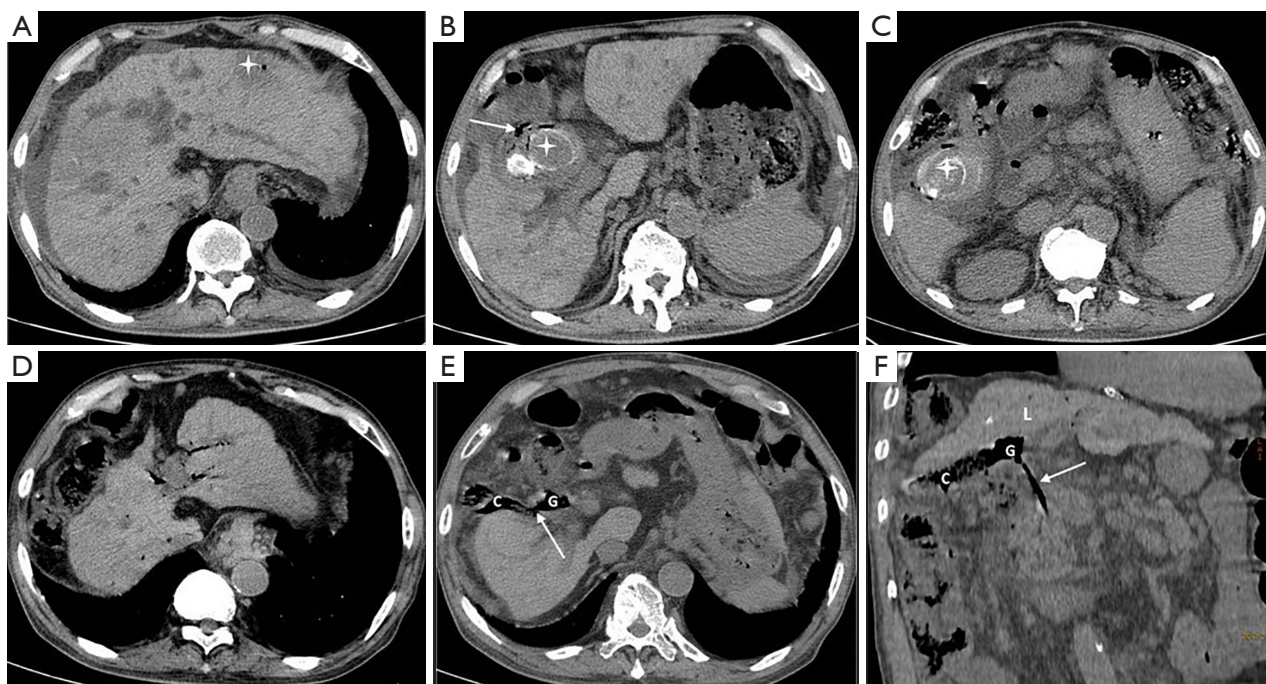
CT images of the cholecystocolic fistula presented from Case 2. (A) The axial abdomen CT image during hospitalization showed the presence of a liver abscess in the left lobe with small bubbles inside (asterisk) and peritoneal effusion surrounding the liver. (B) The axial CT image showed an unclear border between the liver and the gallbladder. The gallbladder wall was thickened and edematous. Multiple stones of mixed densities (asterisk) along with gas (white arrow) were visible within the gallbladder. (C) The axial CT image showed a larger stone (asterisk) at the bottom of the gallbladder. (D) The follow-up axial CT image (2 years later) showed liver cirrhosis, intrahepatic biliary dilation, and pneumatosis. (E,F) The axial and reconstructed coronal CT images clearly demonstrated a fistula (E, white arrow) that formed between the gallbladder and hepatic flexure of the colon. Pneumatosis in the common bile duct was observed (F, white arrow). C, colon; G, gallbladder; L, liver; CT, computed tomography.
